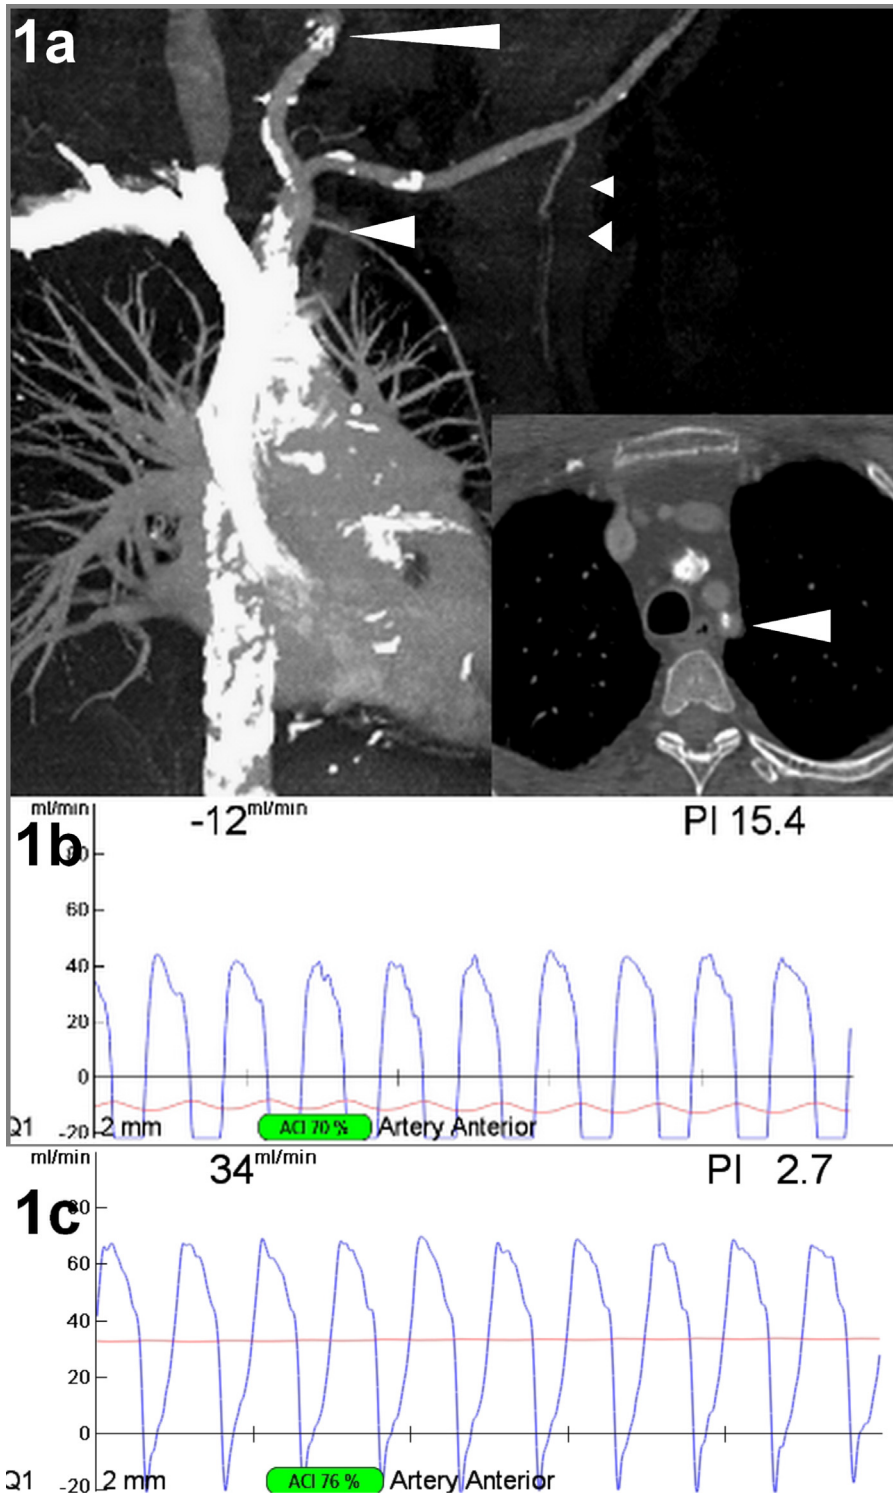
(a) Computed tomography scan shows left subclavian artery calcifications (big arrows + embedded picture), perfused left internal mammary artery (short arrows), and occlusion of left carotid artery (long arrow). (b) Transit time flow measurement (TTFM) with high pulsation index and flow inversion. (c) Correct TTFM results after finishing the complementary left subclavian artery bypass.
